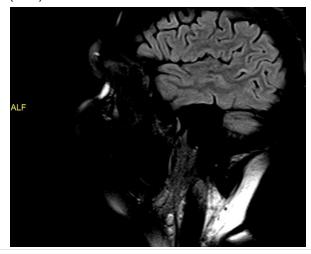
FLAIR: Subtle gyral hyperintensity.
